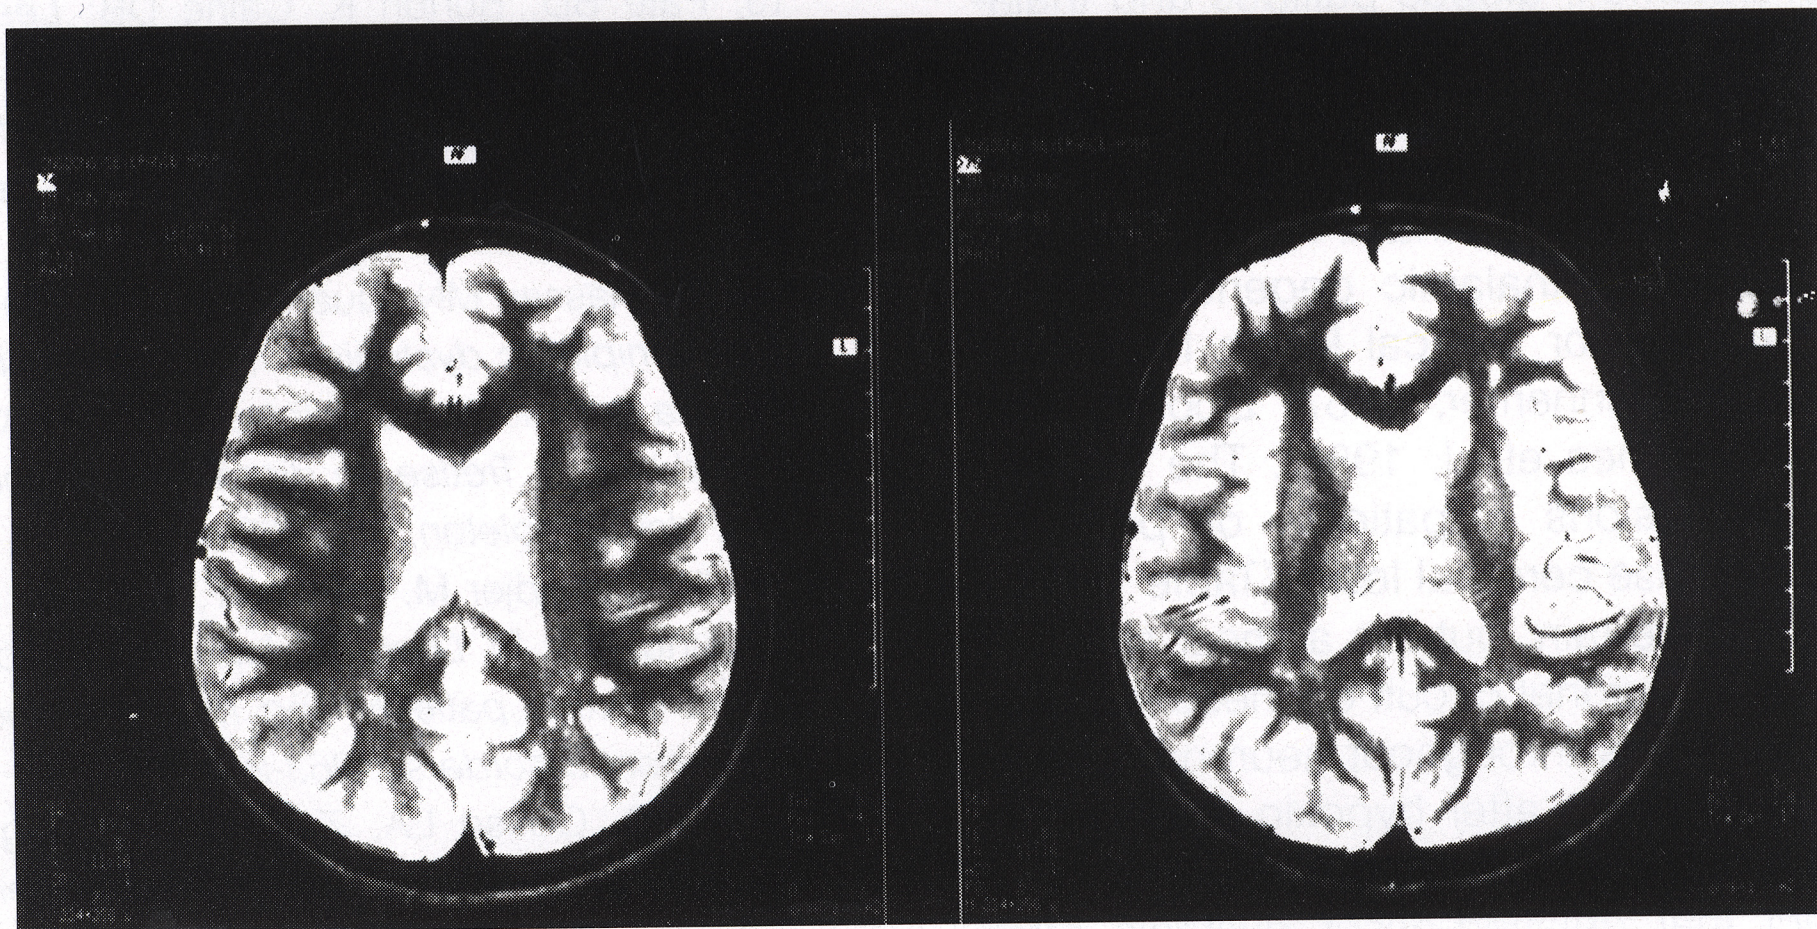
A MRI of the brain of patient 2 showed abnormal high signal intensity in bilateral occipital and parietal deep white matter (repetition time, 3000 msec; echo time, 80 msec).
